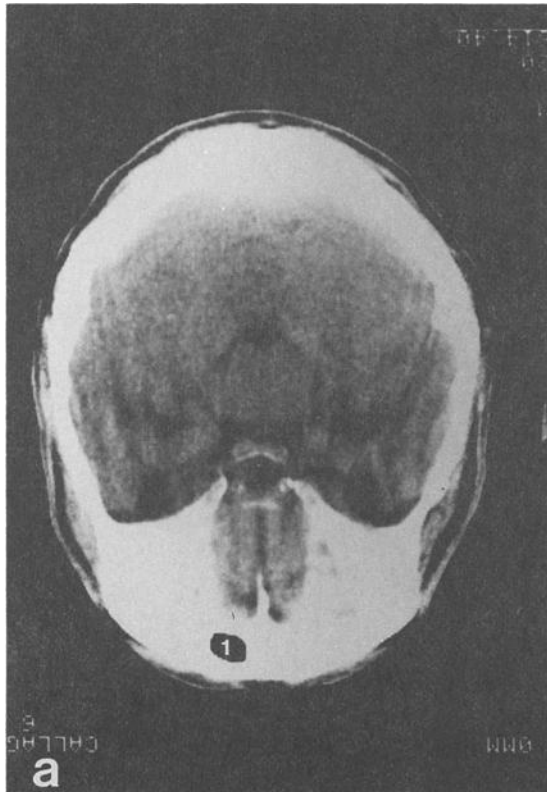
Antemortem axial CT scan demonstrating unilateral, right frontal sinus (1). Taken at the level of the sella turcica and anterior cranial fossa.
